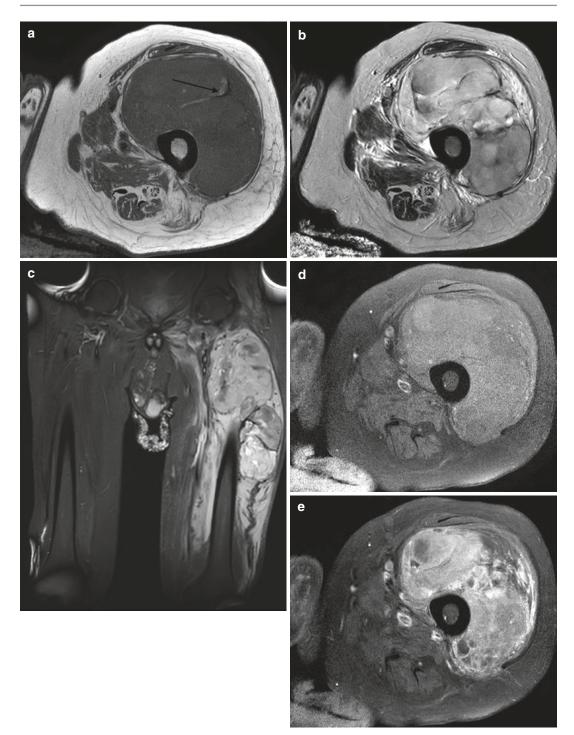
(a–e) *USTS* of the thigh. (a) Axial T1-weighted MR image. (b) Axial T2-weighted MR image. (c) Coronal STIR MR image. (d) Axial pre-contrast T1FS. (e). Axial post-contrast T1FS. The *MRI* features of an *USTS* are non-specific. *USTSs* are commonly intermediate to low intensity compared to skeletal muscle on T1-weighted
